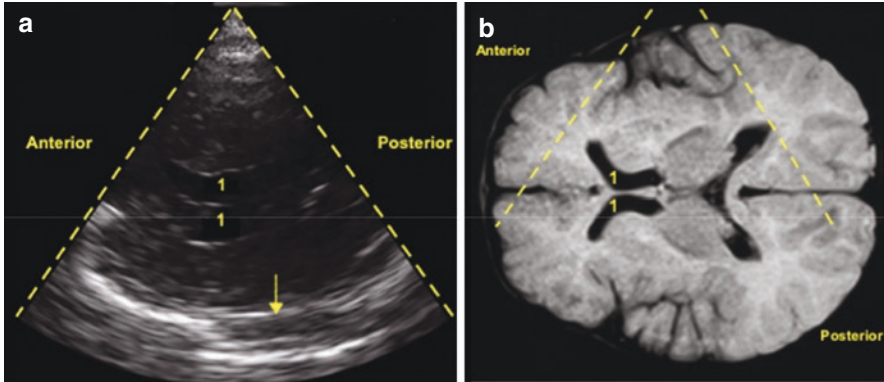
(a) Ventricular plane by TCCS through transtemporal acoustic window: (1) anterior horns of lateral ventricles, (arrow) contralateral skull. (b) Brain MRI: (1) anterior horns of lateral ventricles and ultrasound beam (dotted line). (Author: Camilo N Rodríguez)
